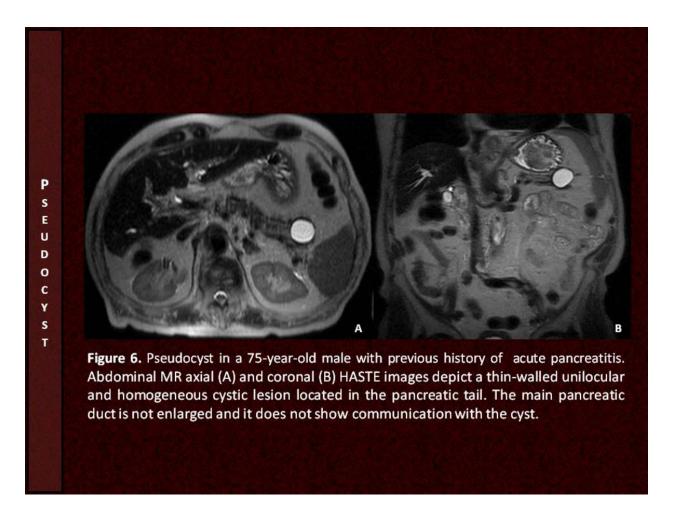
Pseudocyst - MRI
